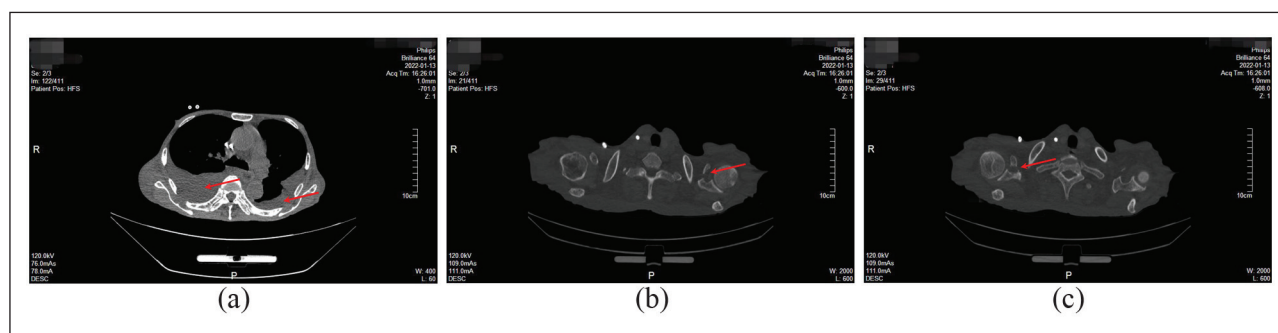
CT scan on 13 January 2022, still indicating bilateral pleural effusion (a, red arrows), and bilateral coracoid process fracture which failed to heal (b and c, red arrows).
